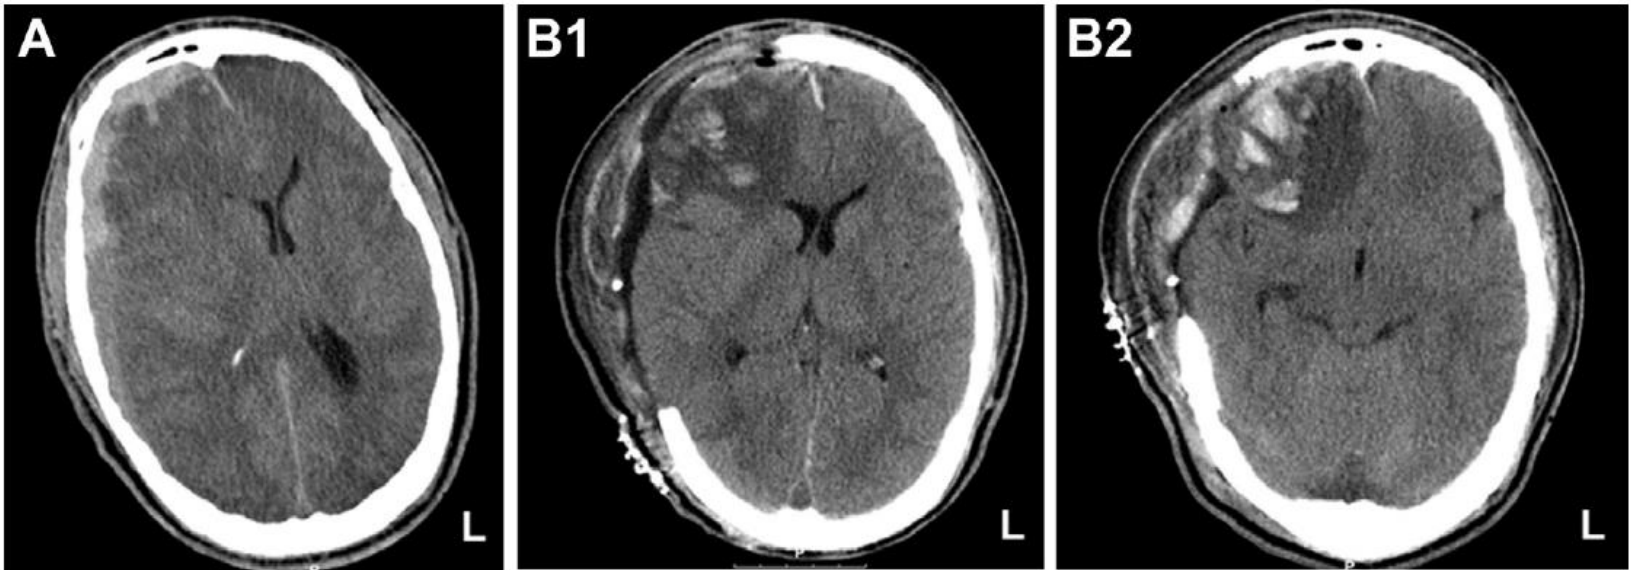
Computed tomography scans from a nonhelmeted snowboarder, who fell on a skiing slope. At admission the Glasgow coma scale score of this patient was 3, with anisocoria. The patient suffered from an acute subdural hematoma causing a midline shift more than 2 cm (A). After urgent decompressive hemicraniectomy the midline shift was almost normalized and the contusions were demarcated (B1, B2).
